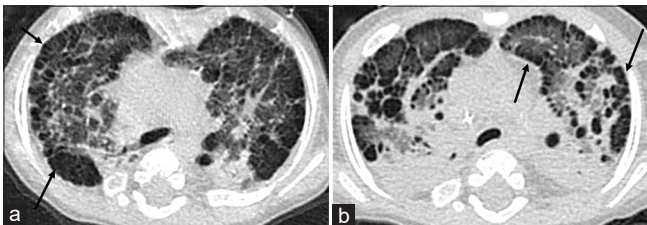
Two axial chest computed tomography images (a and b) in a 10-month-old male with trisomy 21 show extensive subpleural cysts (black arrows) peripherally and along the fissures and bronchovascular bundles
